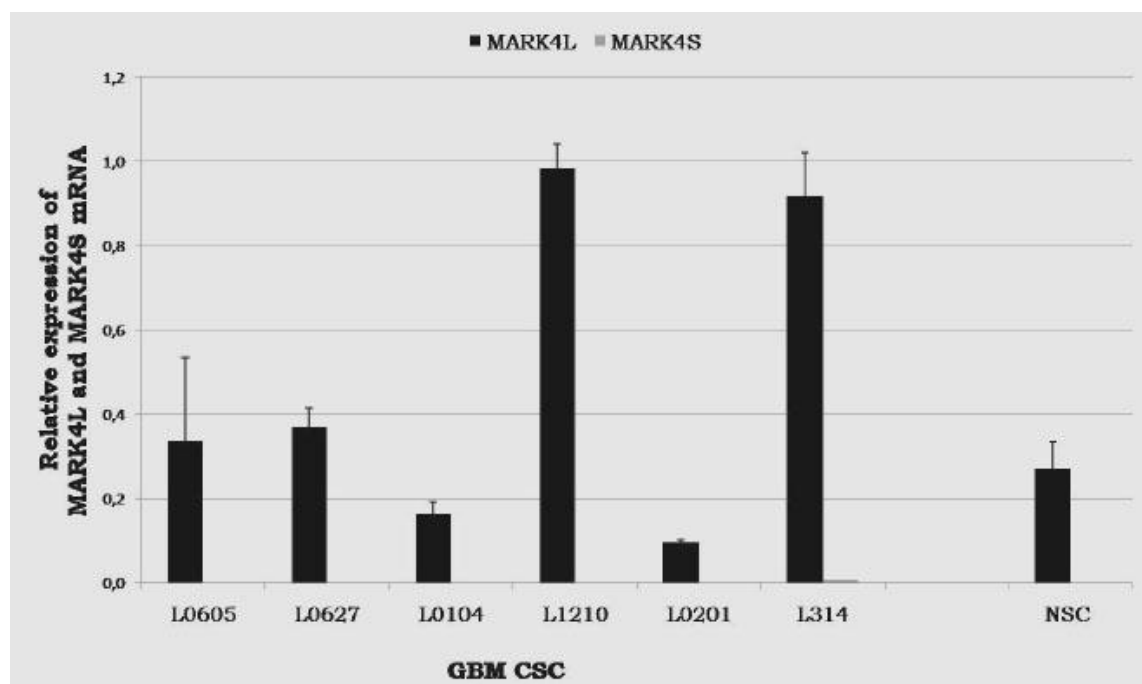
relative expression ($2^{-\Delta\Delta CT}$) of MARK4L and MARK4S in GBM CSC and NSC by Real-time quantitative PCR. Expression levels are referred to Human Normal Brain (HNB), chosen as reference and whose values were set as 1. Expression data are shown as mean \pm standard error.
